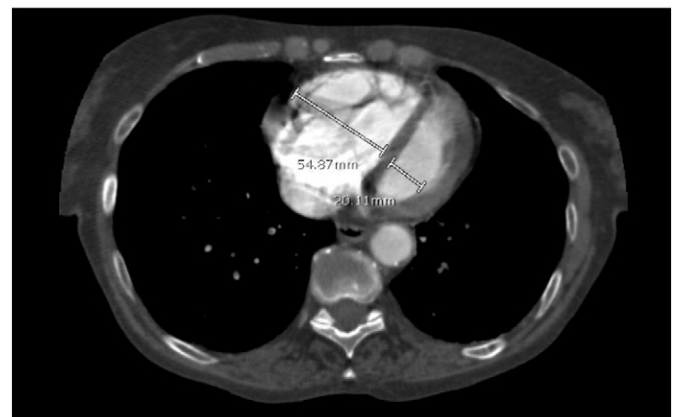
Very high right/left ventricular ratio on a representative CT pulmonary angiogram at the ventricular level. Note the ratio is more than 2.7.
